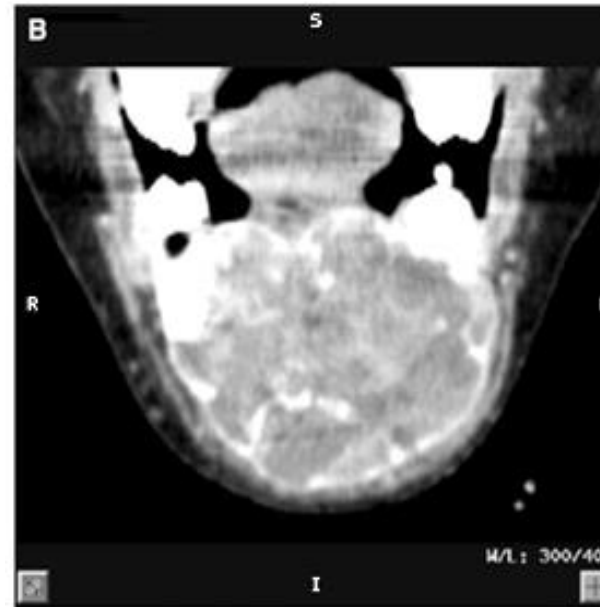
MPR-CT images: axial (A), coronal (B) and sagittal (C) views demonstrate the degree of bucco-lingual and inferior expansion of the lesion in the body of the mandible, as well as the internal trabeculae. The CT images show a large well-demarcated multilocular mass with multiple foci of calcification, involving from the right to the left side of the mandibular body, including the region of the menton.
